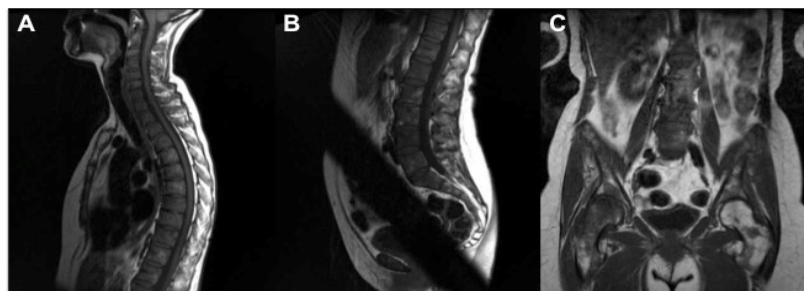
year-old female with invasive lobular carcinoma. T1-weighted MRI demonstrating diffuse marrow replacement by metastases. A. Sagittal image of the cervical and thoracic spine. B. Sagittal image of the lumbo-sacral spine. C. Coronal image of the abdomen and pelvis demonstrating right femoral head avascular necrosis.
